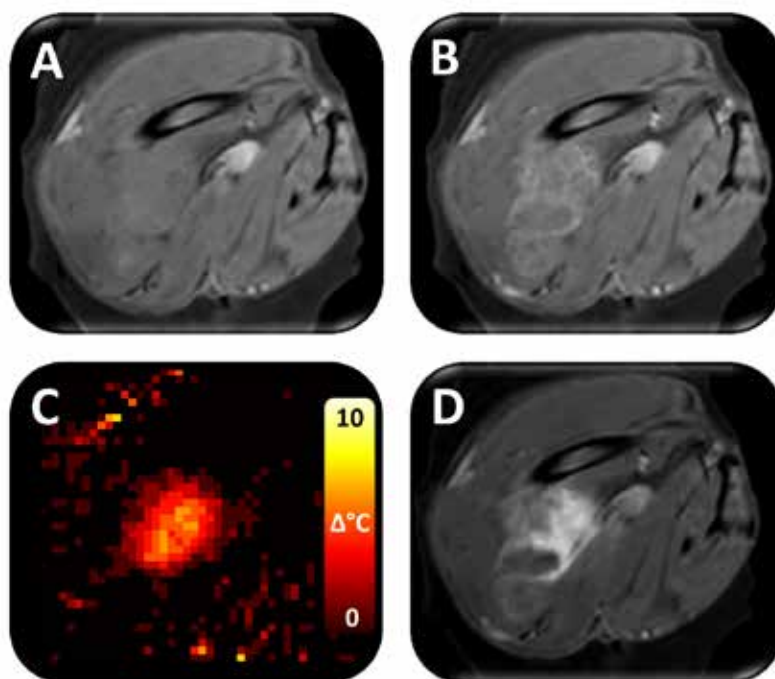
MR signal intensity before and after iLTSL injection and heating with MR-HIFU. A) Signal intensity before iLTSL injection. B) Signal intensity after iLTSL injection. C) Example of a temperature elevation map during heating. D) Signal intensity after four 10-minute heating sessions. Preferential contrast agent release limited to the heated region is evident. A, B, and D depict  $T_1$ -weighted MR images.
